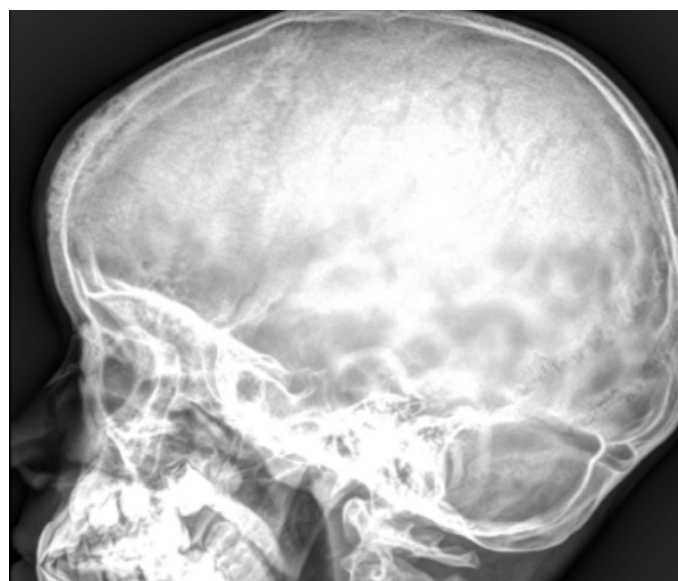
Osteolytic lesions of the frontal bone on skull radiography
